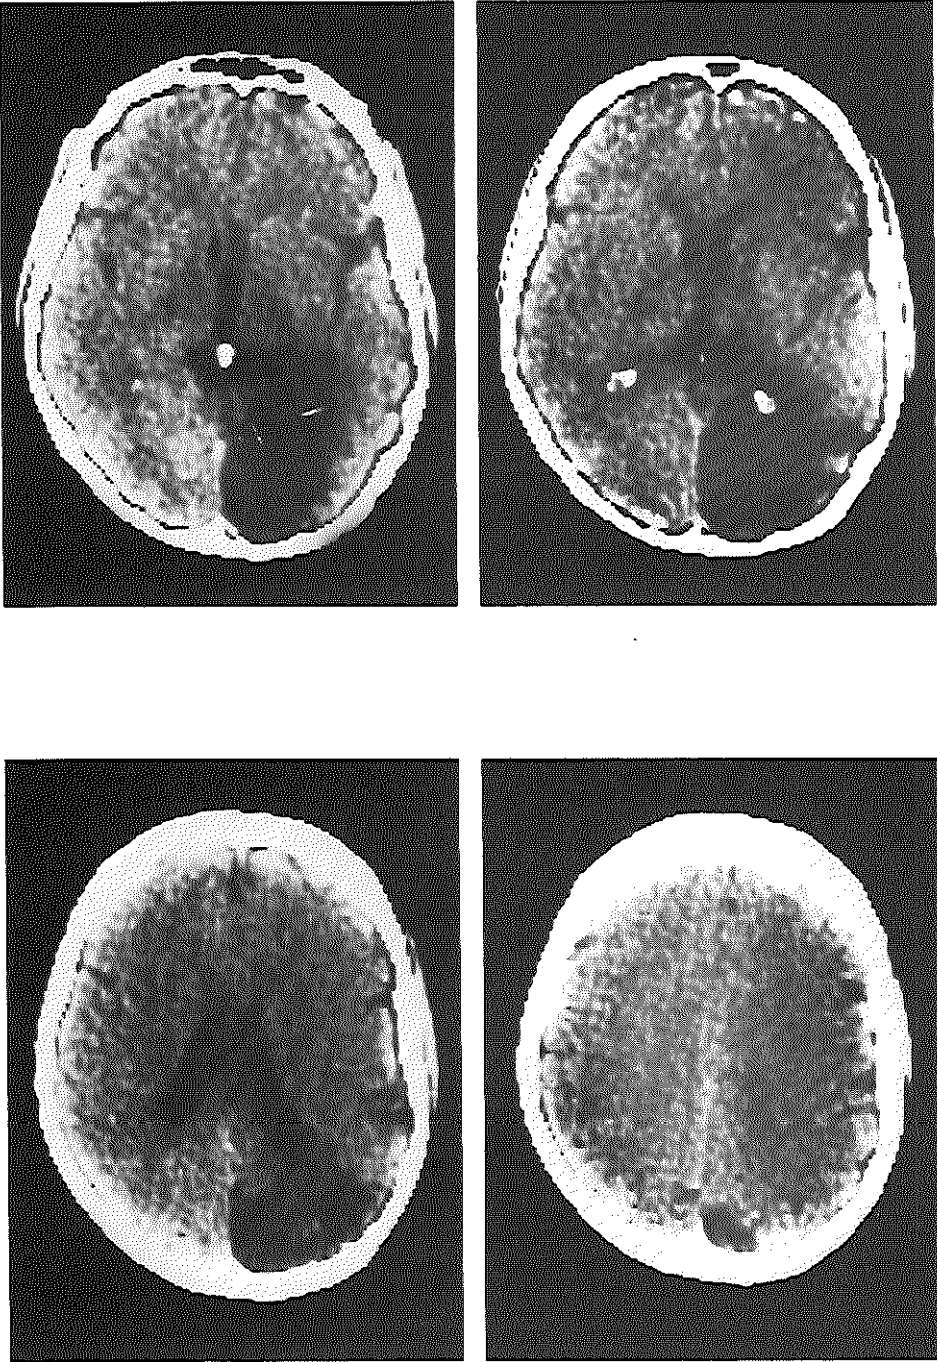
CT scan of a patient with a large lesion.
